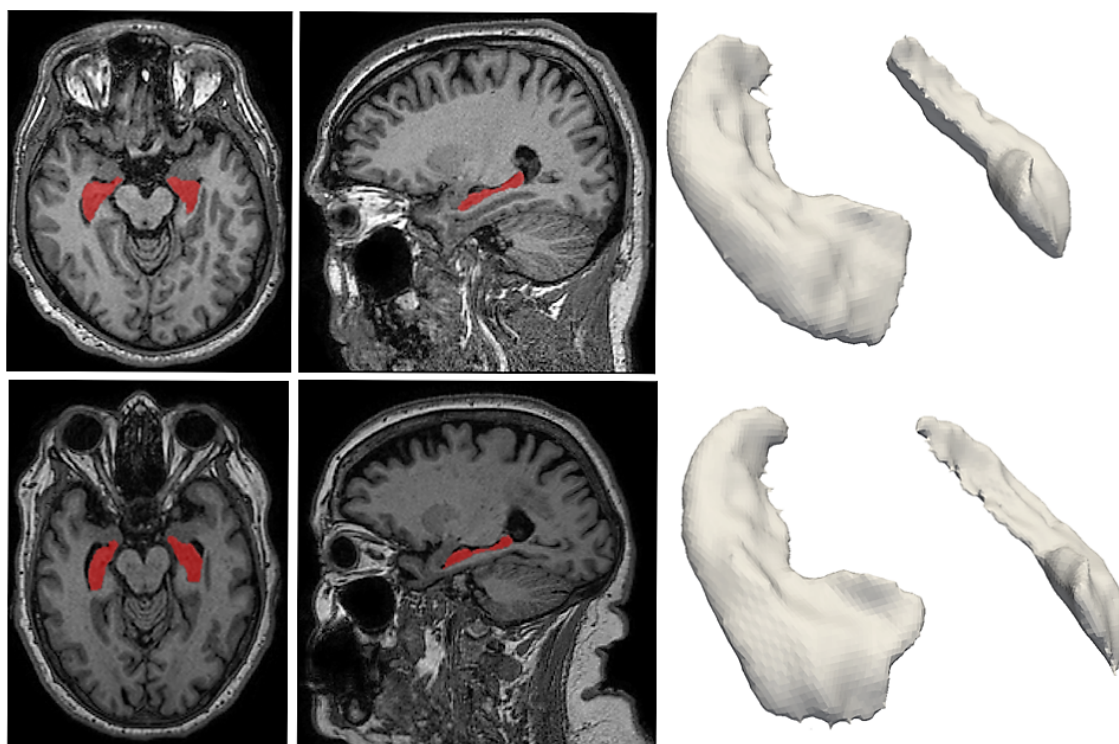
Hippocampi automatically segmented from MR images of a healthy subject (top row) and MCI patient (bottom row). Axial and sagittal view of segmentations overlaid on their respective raw images are shown in the left and centre columns respectively and the surfaces generated from these are depicted in the column on the right.
